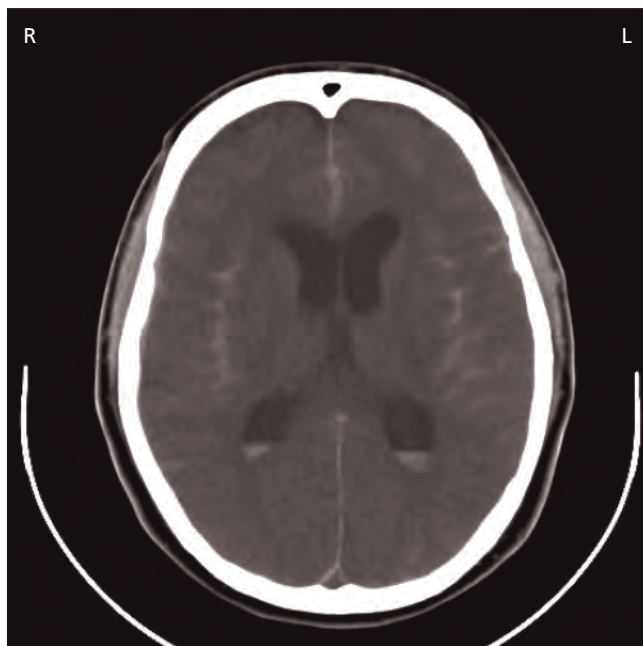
Diffuse subarachnoid and intraventricular blood (unenhanced CT).
